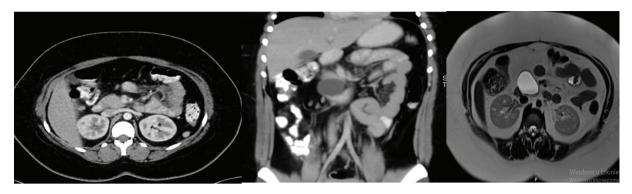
Abdominal computed tomography and magnetic resonance images demonstrating a cystic lesion in the head of the pancreas, and agenesis of the pancreatic neck, trunk and tail
